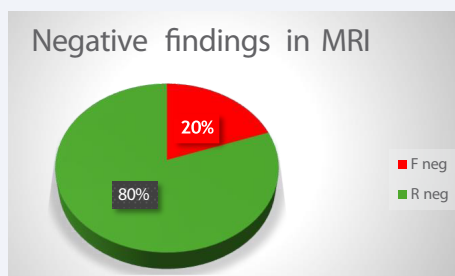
False-negative and true-negative findings in HR breast MRI.
